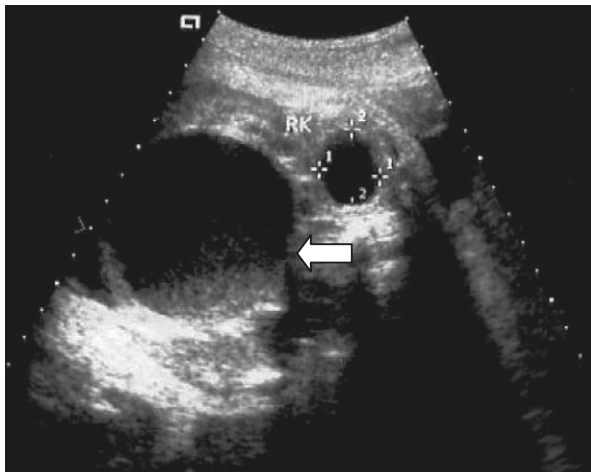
Ultrasonography on transverse view of the lower abdomen of the fetus, with the right kidney (RK) exhibiting hydronephrosis and a cystic abdominal mass (arrow) measuring 101 × 63 mm.
